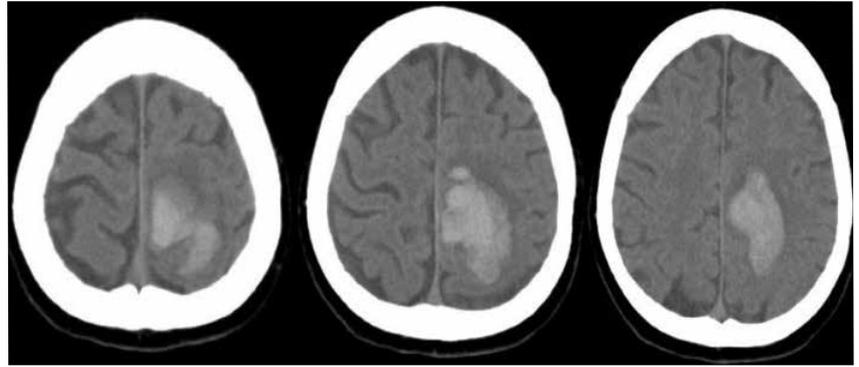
A parasagittally located, 5x3x3 cm sized parenchymal hematoma was found in the frontoparietal convexity in the cranial CT performed at the admission.
